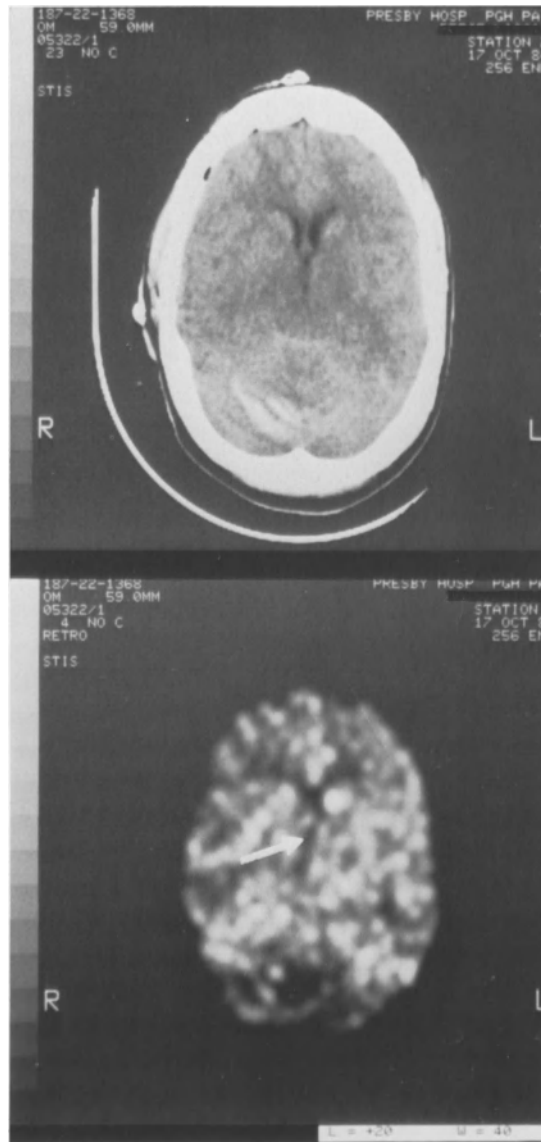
a. Following clipping of a basilar tip aneurysm this woman was paretic on her right side with dysconjugate gaze. While the CT scan disclosed no significant abnormality, the accompanying CBF study revealed a small region with absent perfusion within the right thalamus
